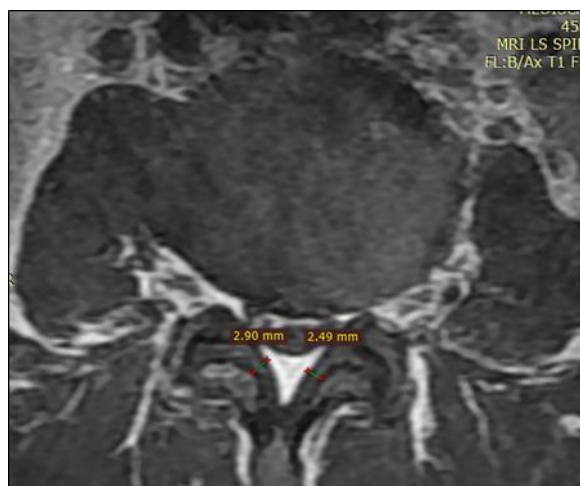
Showing measurement of LF thickness on T1-weighted axial images
